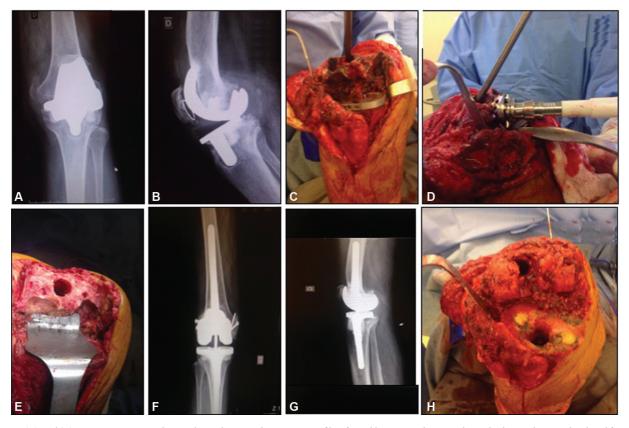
(A) and (B) anteroposterior radiographs and aseptic loosening profile of total knee prosthesis with marked osteolysis in the distal femur; (C) Intraoperative aspect of the femoral bone defect; (D) Preparation of the graft with an acetabular cutter; (E) Intraoperative appearance after debridement; (F) and (G) Postoperative radiographs of the structural homologous graft fixed with screws in both condyles of the distal femur and revision semi-constricted implants; (H) Intraoperative appearance after using homologous bone graft.
